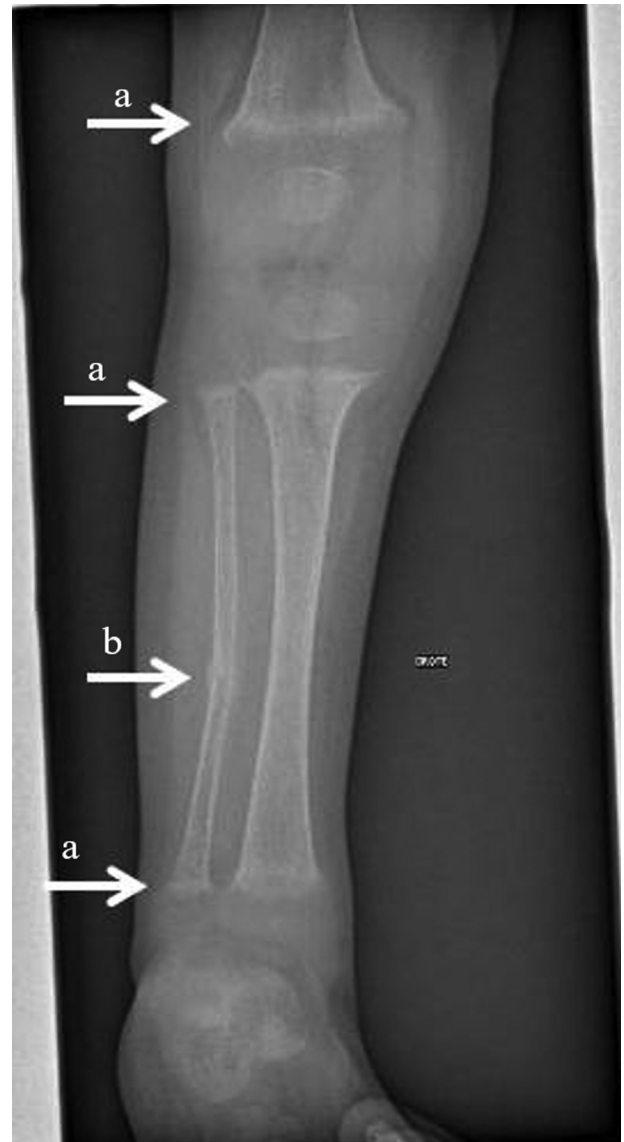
X-ray of the right leg: cupping, splaying, and fraying of metaphysis, widened growth plates (a); cupping, splaying and fraying of metaphysis, widened growth plates; (b): diaphyseal peroneal fracture with continuous periosteal appositions and rough of bony callus; diffuse osteopenia.
